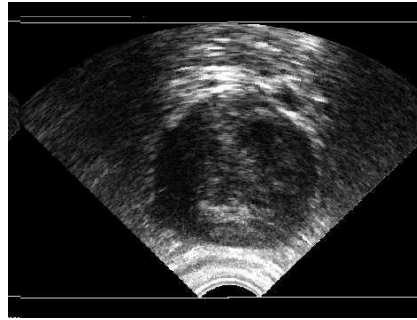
Transrectal ultrasound image of the prostate (Awad, 2007).
